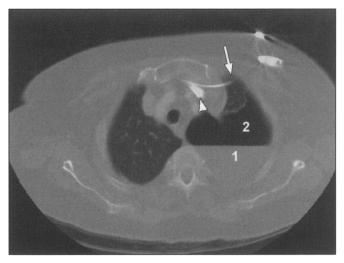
CT-scan with contrast showing the pacemaker electrode (arrow) passing through the left lung into the innominate vein (arrow head). The haematothorax (1) and pneumothorax (2) are also visible.
